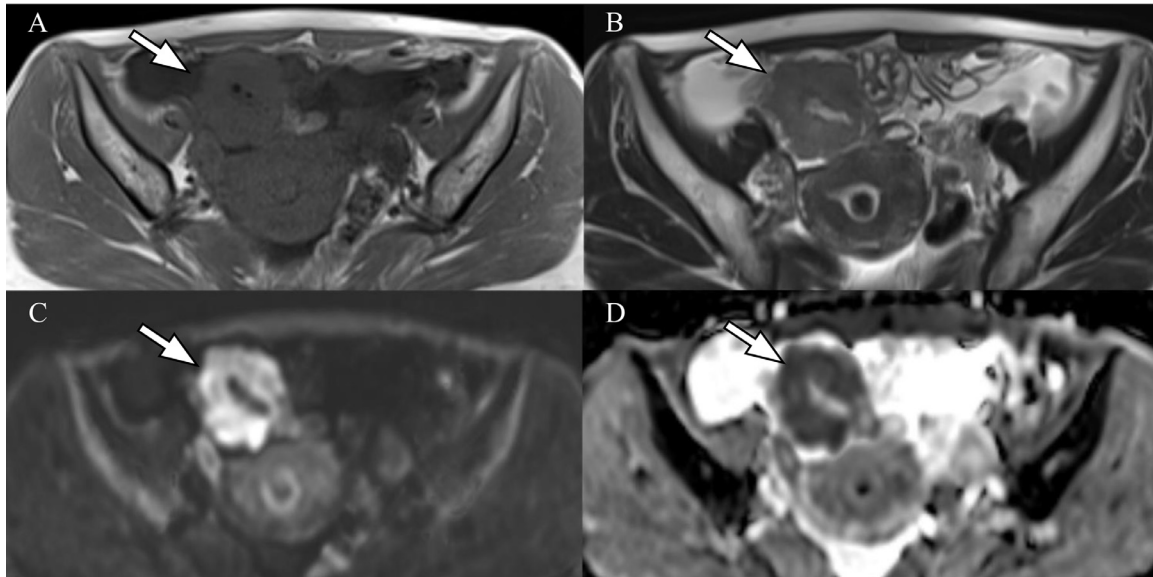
Magnetic resonance imaging of the pelvis shows that the tumor exhibits intermediate signal intensity on T1-weighted imaging (A), moderate hypointensity on T2-weighted imaging (B), marked diffusion restriction with hyperintensity on diffusion-weighted imaging (C), and diffusion restriction on the apparent diffusion coefficient (ADC) map (D) (arrows). The average ADC value is $0.8 \times 10^{-3} \text{ mm}^2/\text{s}$.
